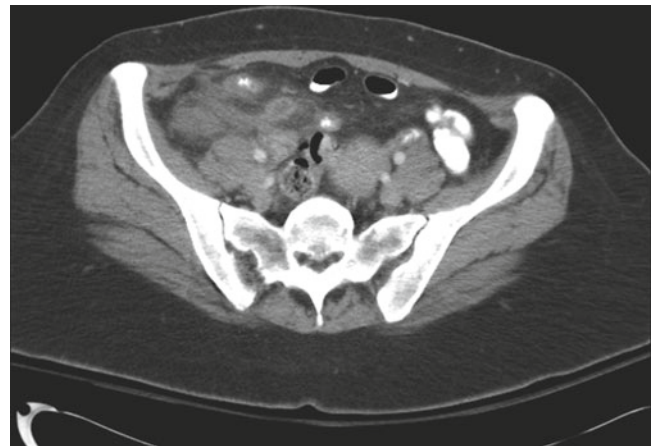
Acute appendicitis. CT abdomen and pelvis demonstrates a dilated fluid filled appendix with enhancing wall and adjacent fat stranding
